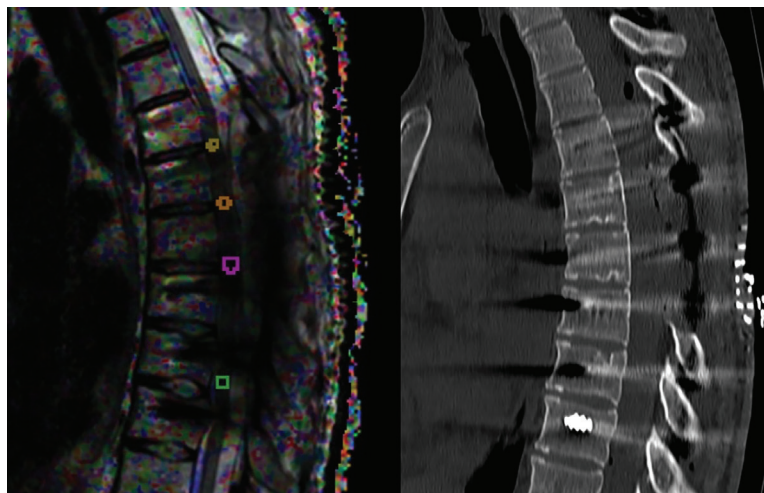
Post-operative CT scan and MRI with diffusion tensor imaging showing successful spinal cord decompression, accurate placement of instrumentation, and adequate correction of the kyphotic deformity
